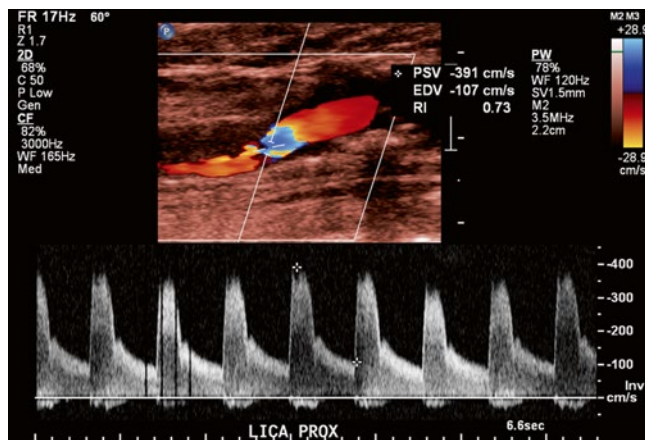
Duplex ultrasound of severe internal carotid artery stenosis: PSV of 391 cm/s and EDV of 107 cm/s with significant carotid plaquing
